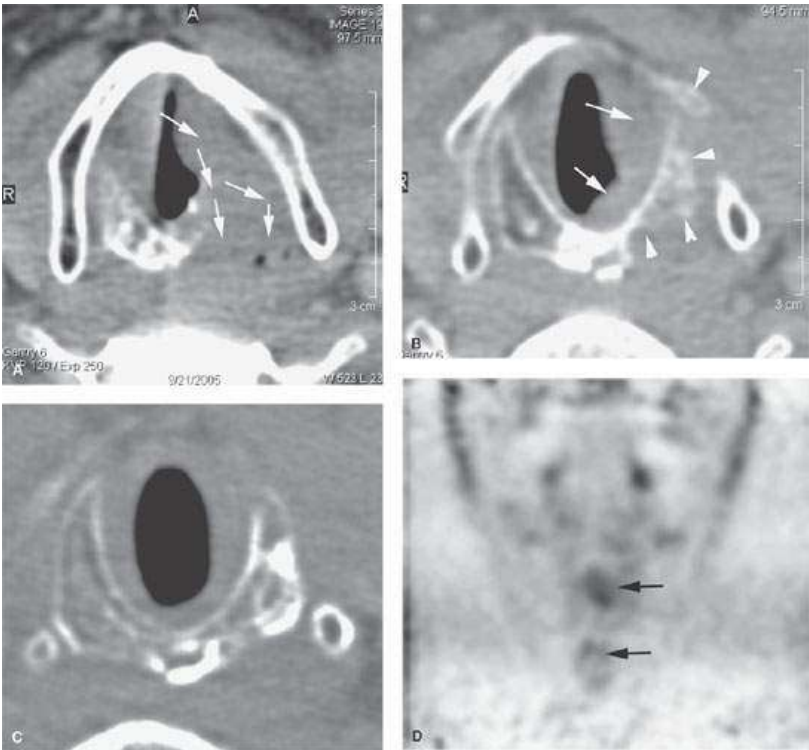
A patient treated with radiotherapy for laryngeal carcinoma. The contrast-enhanced computed tomography study done in follow-up shows anatomic evidence of recurrence. A: Tumor of the true cord infiltrating the paraglottic space and destroying the thyroid and arytenoid cartilages (arrows). B: Sections in the mid subglottis showing endoluminal tumor (arrows) and destruction of the thyroid and cricoid cartilages (arrowheads). C: Section in the low subglottis showing cricoid cartilage sclerosis related to involvement by tumor. (NOTE: All of this recurrent disease was submucosal. Fluorine-18 2-fluoro-2-deoxy-D-glucose positron emission tomography [FDG-PET] was done even though diagnosis of recurrence was virtually certain since no features of necrosis were present. D: FDG-PET showing several areas of hypermetabolic activity in the larynx (arrows). Total laryngectomy showed extensive recurrent tumor.)
